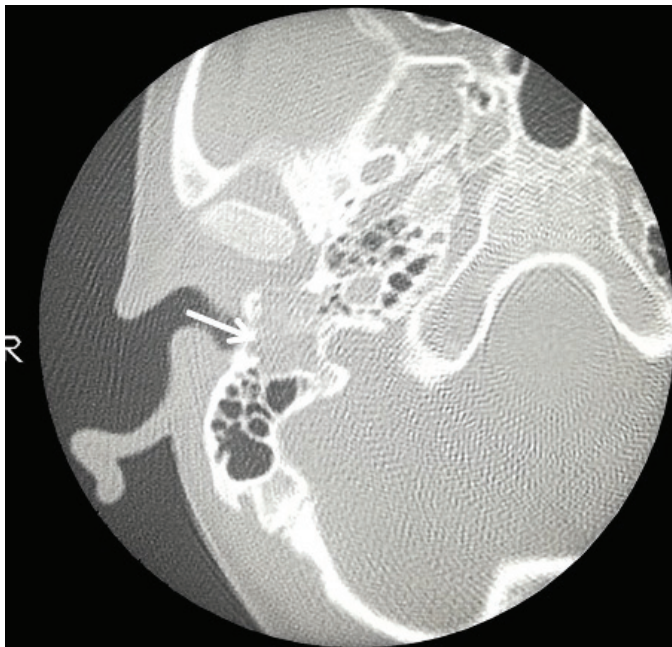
Axial thin-section non-contrast CT image of temporal bone showing destructive and expansile lesion in right temporal bone (arrow)
